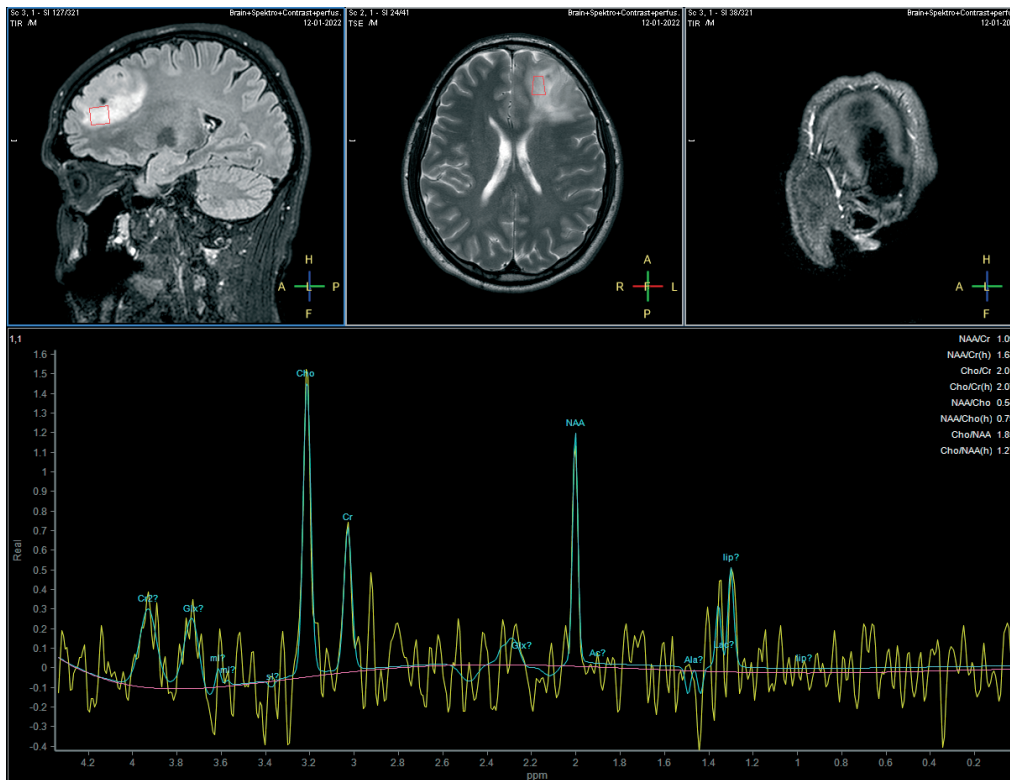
Magnetic resonance imaging image
